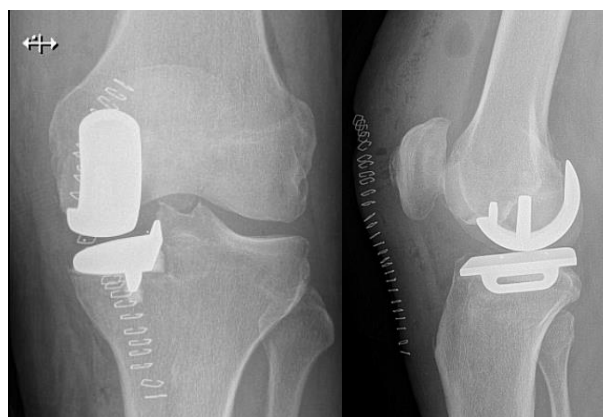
c-d. — Radiographs immediately after placement of a cemented partial medial knee prosthesis.
